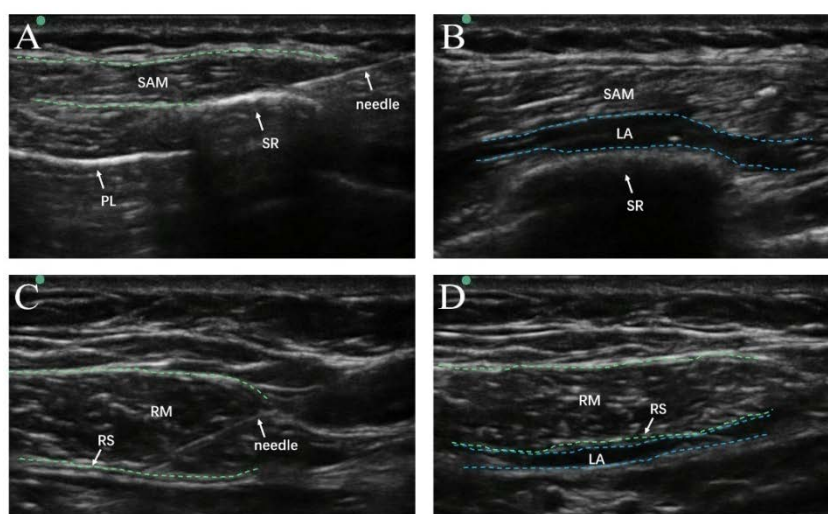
Ultrasound-guided SAPB and RSB. (A) Ultrasound-guided SAPB. (B) A local anesthetic was injected between the external intercostal and the SAM. (C) Ultrasound-guided RSB. (D) A local anesthetic was injected between the deep side of the RM and the posterior RS. SAPB, serratus anterior plane block; RSB, rectus abdominis sheath block; SAM, serratus anterior muscles; RM, rectus muscle; RS, rectus sheath; PL, pleural line; SR, the seventh ribs; LA, local anesthetic
